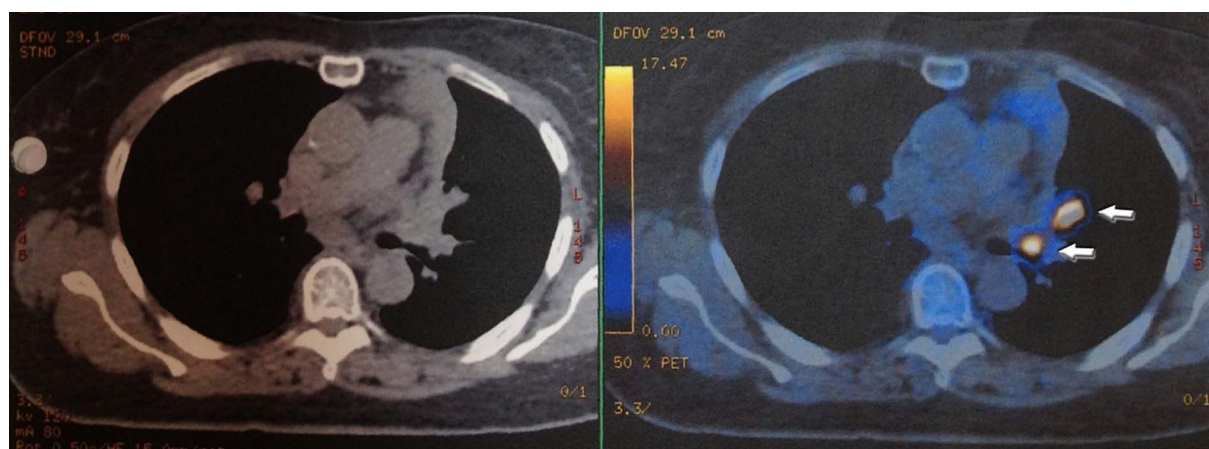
Positron emission tomography-CT scan showing a hypermetabolic lung lesion near the left hilum and an adjacent hypermetabolic lesion suggestive of secondary nodal involvement (white arrows).
